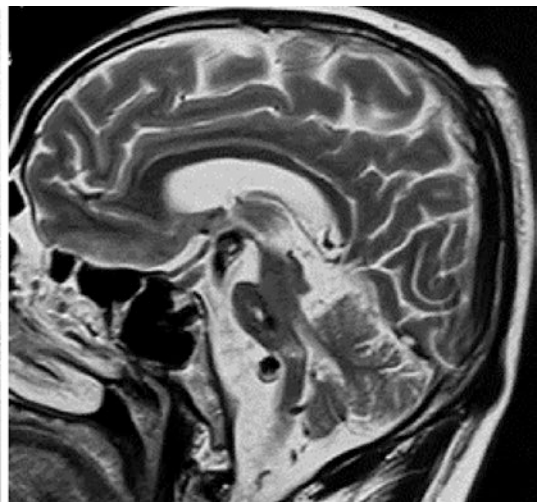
A patient with dolichoectasia of the vertebrobasilar artery presented with symptoms of compression of brain stem. MRI revealed the compression of brain stem without mass
